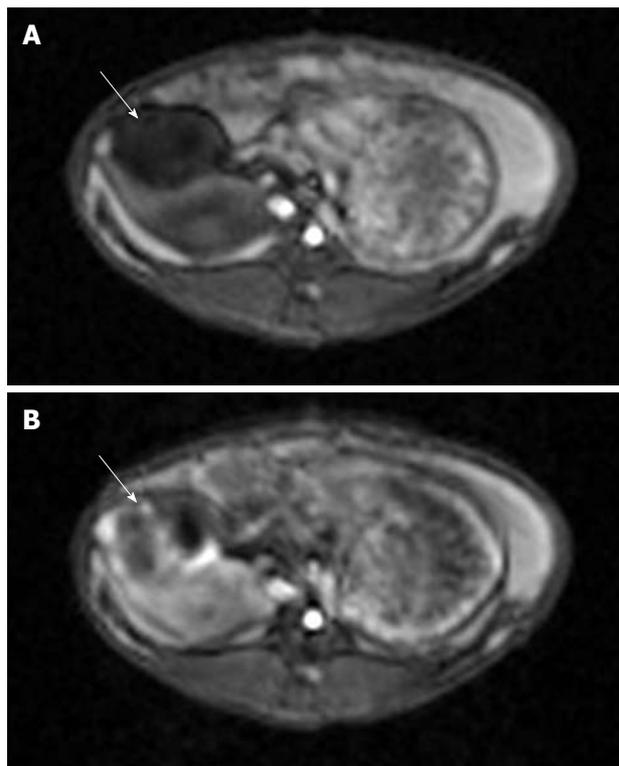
T1-weighted gradient-echo magnetic resonance [taken before (A) and after (B) TRIP imaging occurred]. Each image shows a VX2 tumor (solid arrows) located in the pancreas. Note the areas of increased perfusion to the viable tumor periphery in image B.
